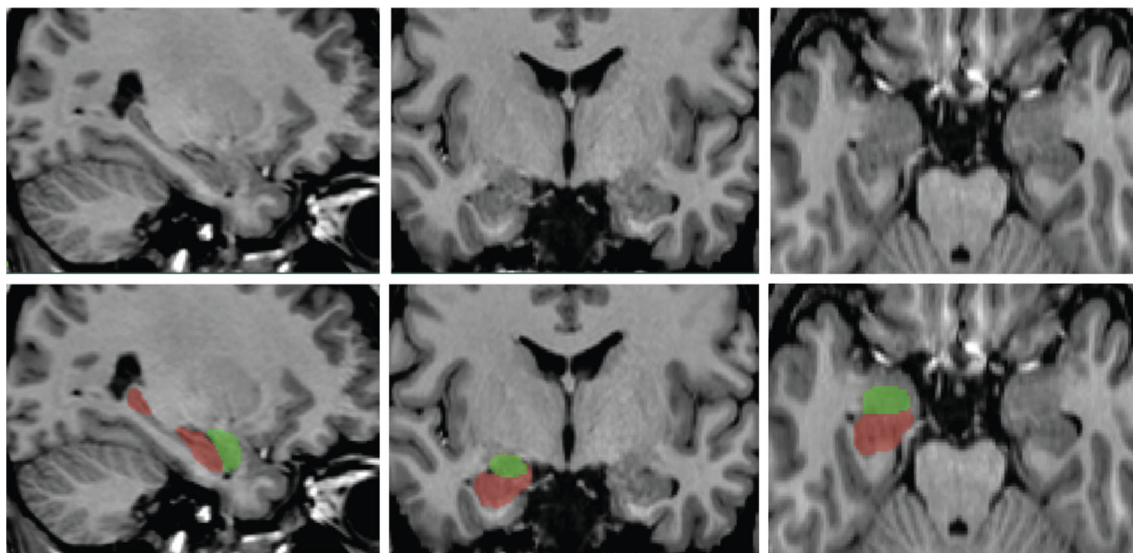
Manual labeling of mesiotemporal structures. T1-weighted MR image on the three orthogonal planes (*top*) and labels of hippocampus (*red*) and amygdala (*green*) overlaid on the image (*bottom*)
